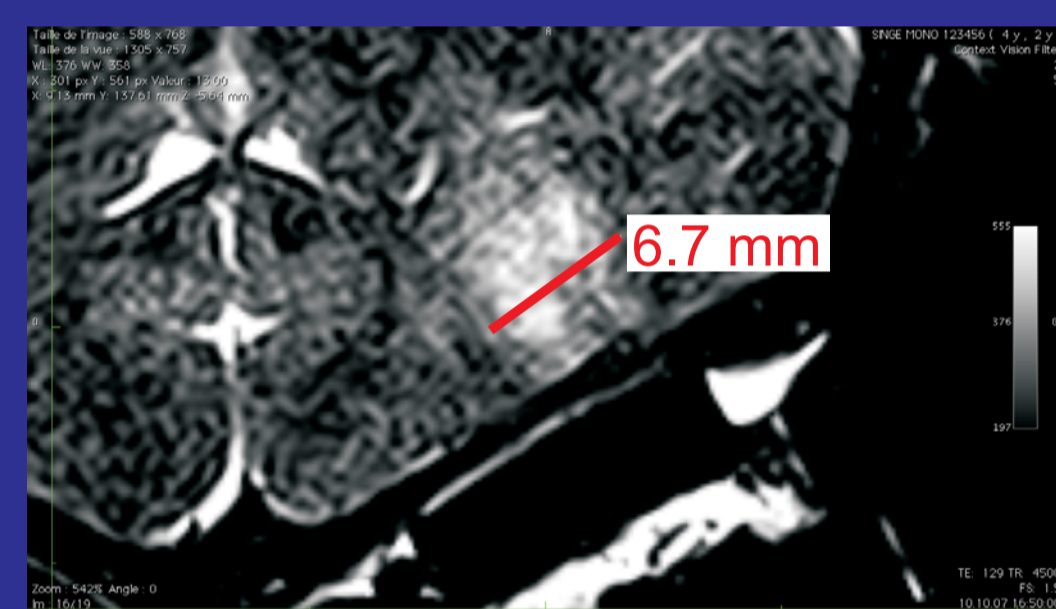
MRI showing the medio lateral extent of the lesion in Mk-AM
